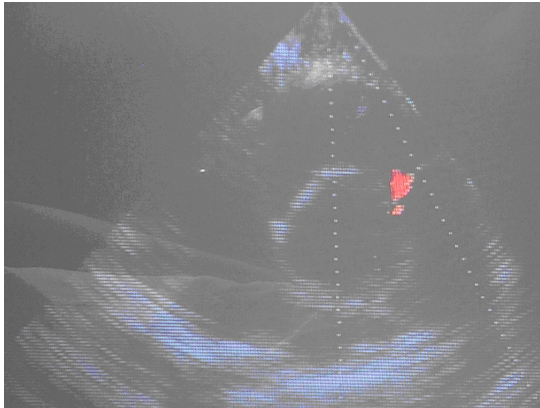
Echocardiography picture of the patient showing aortopulmonary window
